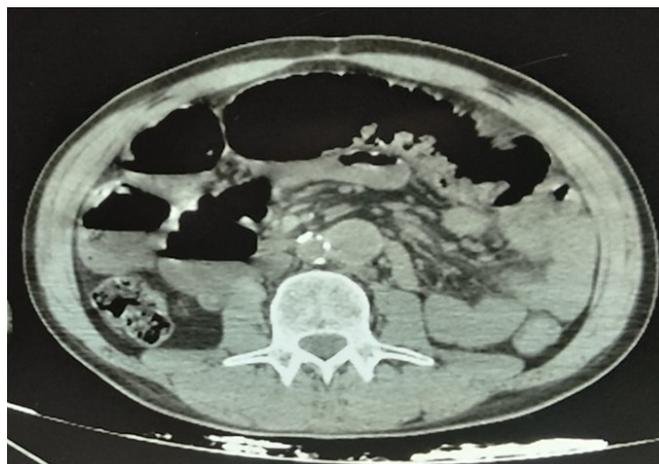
A et B: Abdominal CT scan showing distended small bowel loops with adhesion of the small bowel to the aortobifemoral bypass
